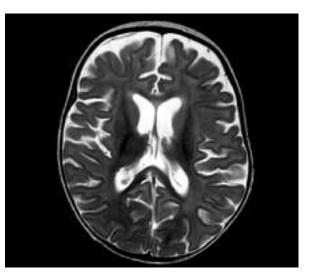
SE/T2 weighted MR images – myelination pattern seen in internal capsules and partially in corpus callosum. The remaining brain structures do not show a proper myelination process. Increased cerebral sulci with increased subarachnoid spaces in frontal areas.
